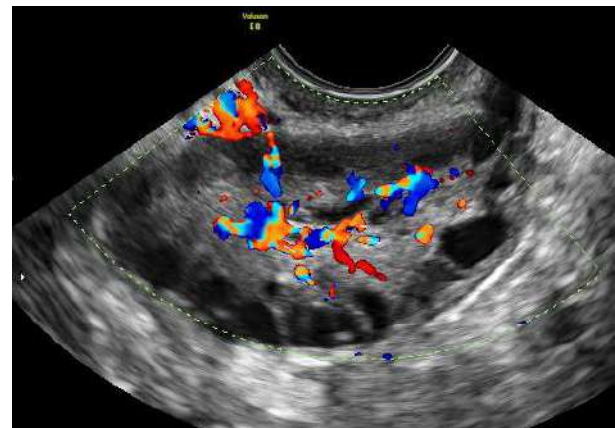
colour Doppler showing ovarian stromal flow.
